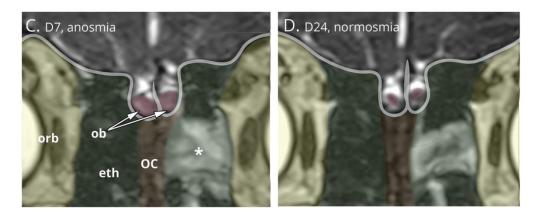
Transient olfactory bulb oedema as shown in coronal 3D MRI T2-weighted imaging (1.5T) during anosmia (day 7; C) compared to recovery (day 24;D). Olfactory bulb (ob; pink) displays transient volume and signal increase, olfactory cleft oedema (OC; brown), and focal left ethmoid (eth; green) sinusitis (*), and normal cranial fossa (grey line) and orbit (orb; yellow). Reproduced from Figure 1 C and D with permission from Laurendon et al9.
